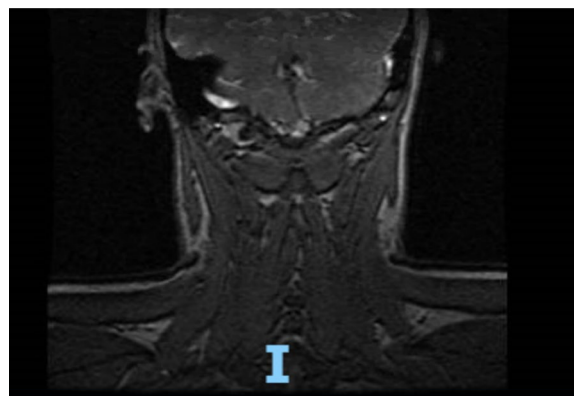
MRI showing foci of nodular enhancement
